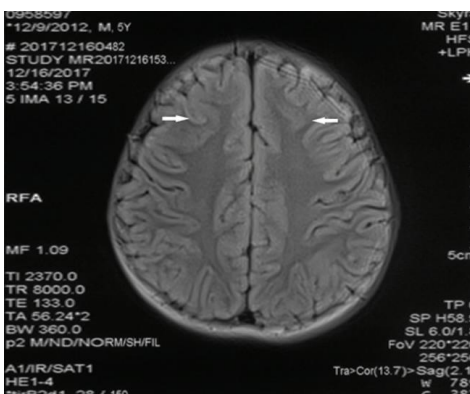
T₂ FLAIR 轴位,双侧额叶可见带状灰质信号,右著
